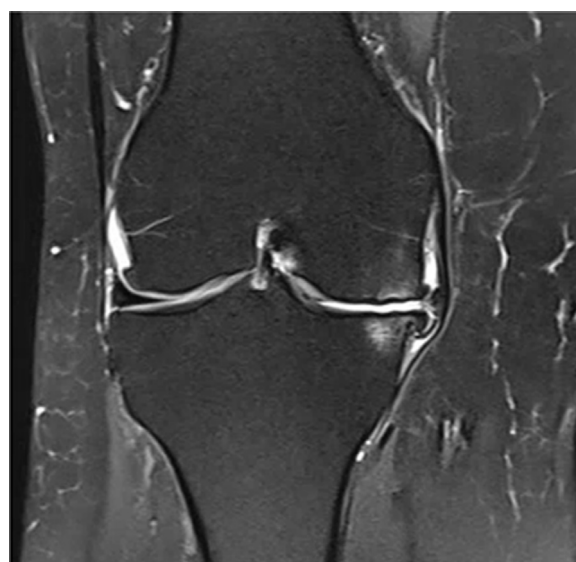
Preoperative magnetic resonance imaging confirmed the indication.
